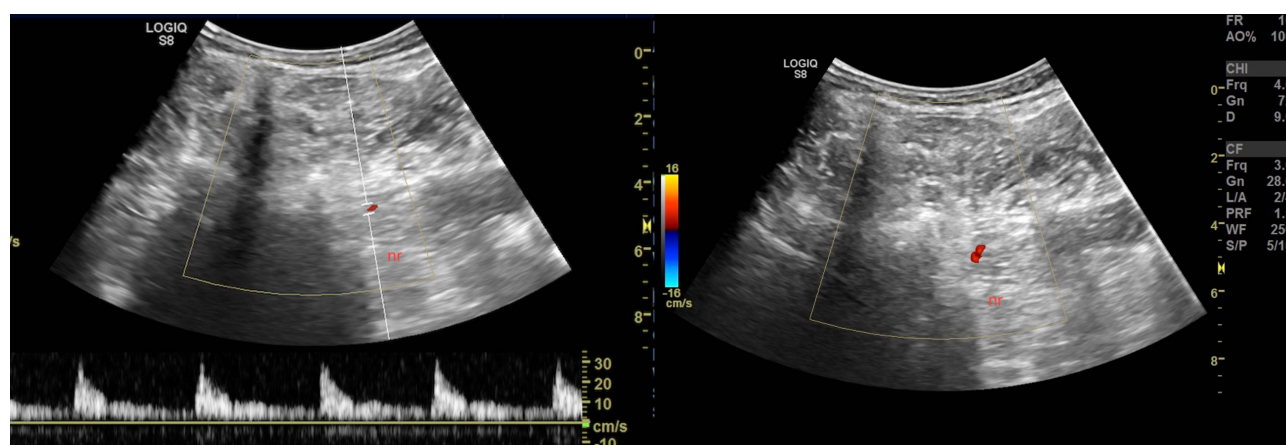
Color duplex and power Doppler demonstrating spinal segmental artery. This could help in directing the needle to avoid the vessel. "nr" indicates nerve root.
